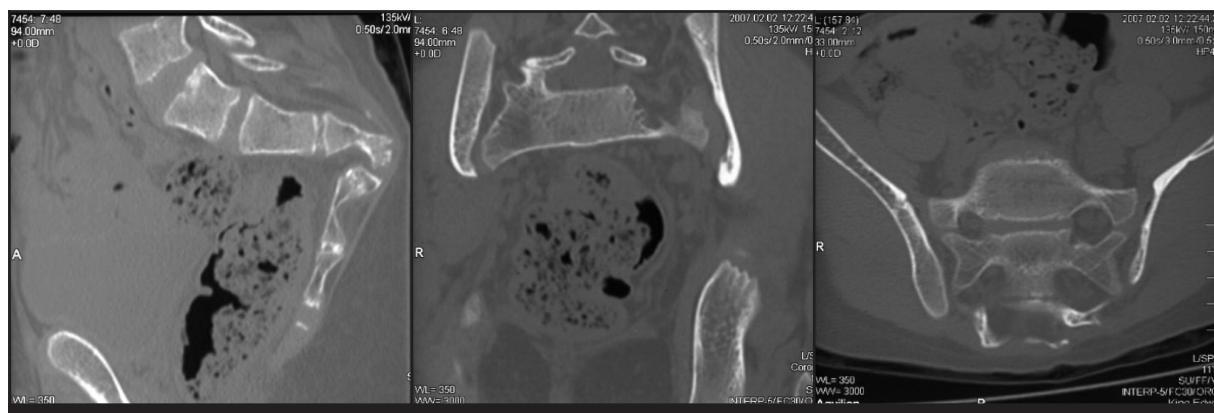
CT sagittal Shows pathological fracture with enlarged neural foramina on the left side
